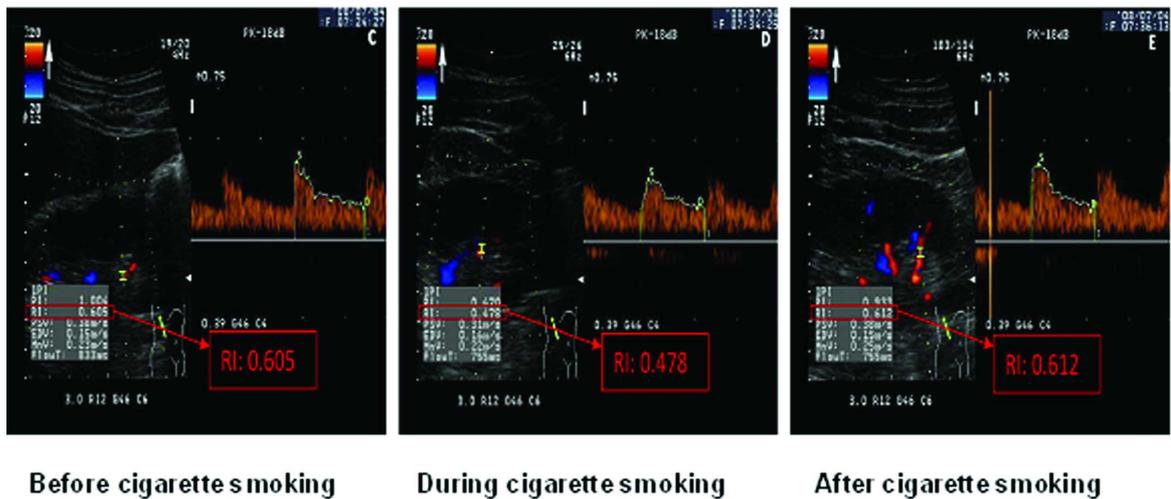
Original Doppler spectrum and acute changes in resistance index of a human segmental renal artery in response to smoking.
